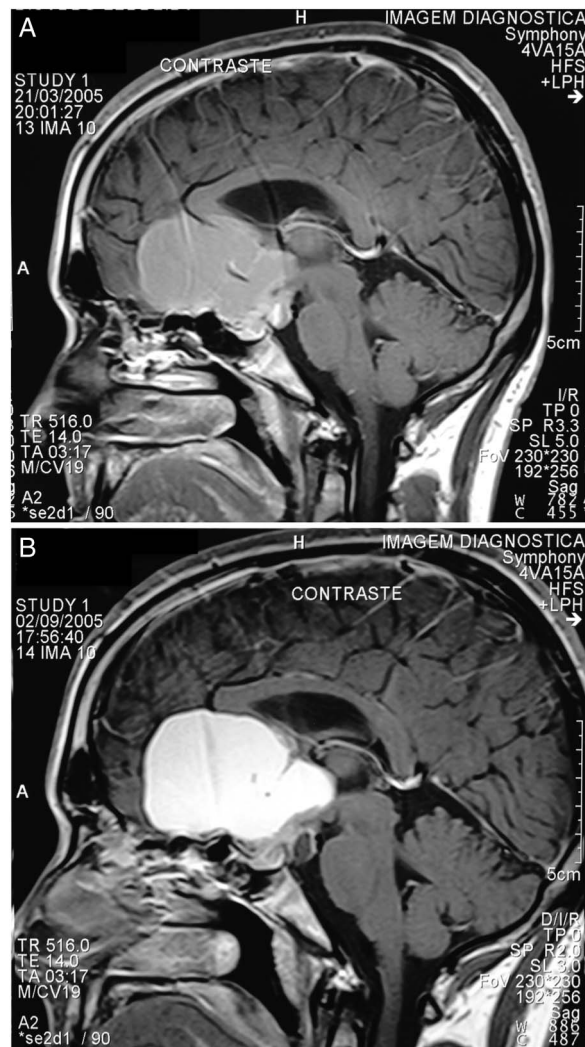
(A) MRI at 6 months of follow-up. (B) MRI at 12 months of follow-up.
